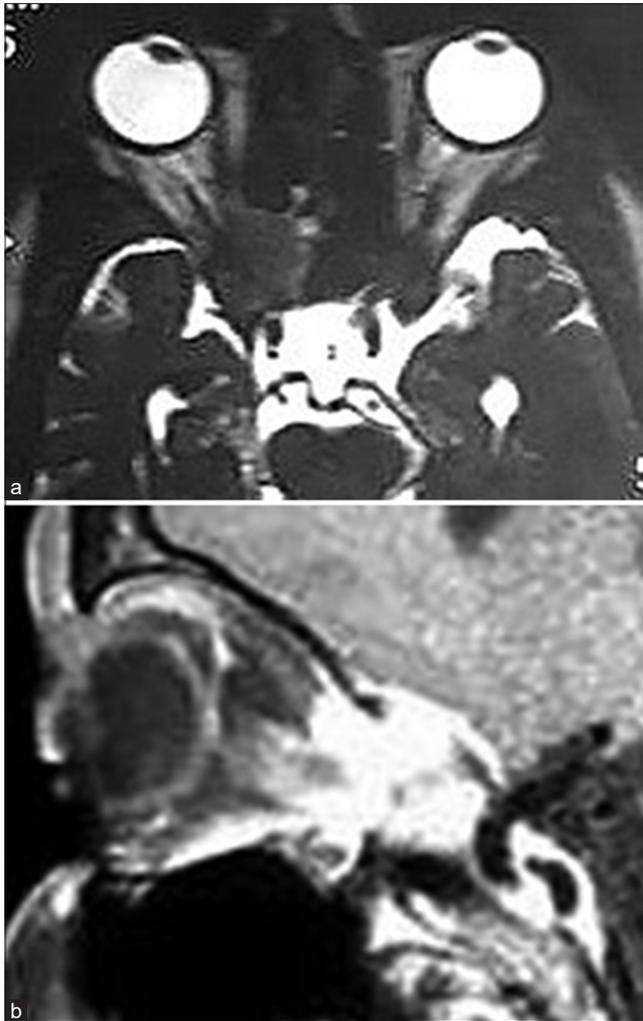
(a) (T1-weighted sagittal MRI showing) and (b) (T2-weighted sagittal MRI showing): Altered signal intensity lesions involving the right orbital apex encasing the right optic nerve in the optic canal and extending into the sphenoid sinus and posterior ethmoidal air cells
